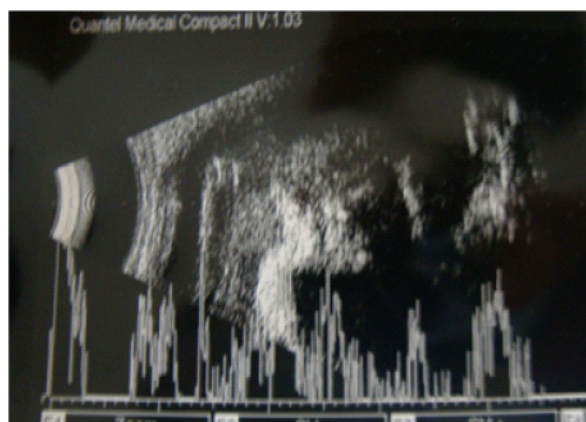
Ultrasonography result of retinoblastoma case, there is a density higher than the sclera with high echo spike
